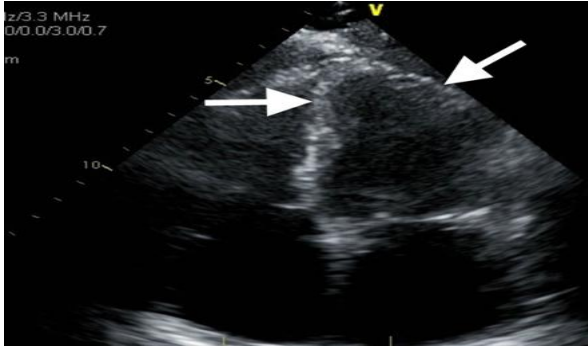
Two dimensional Echocardiographic Apical four-chamber view demonstrating apical ballooning with basal hypercontractility.
